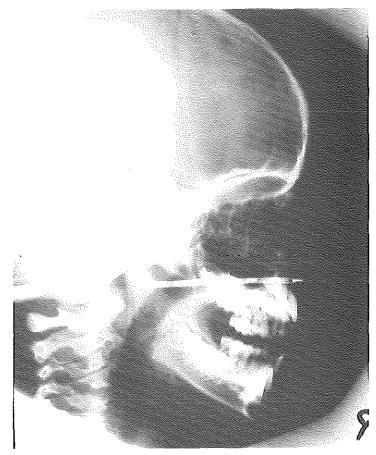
Lateral skull X-ray with calibrated placebo applicator in situ (m, 5.1 yr).
